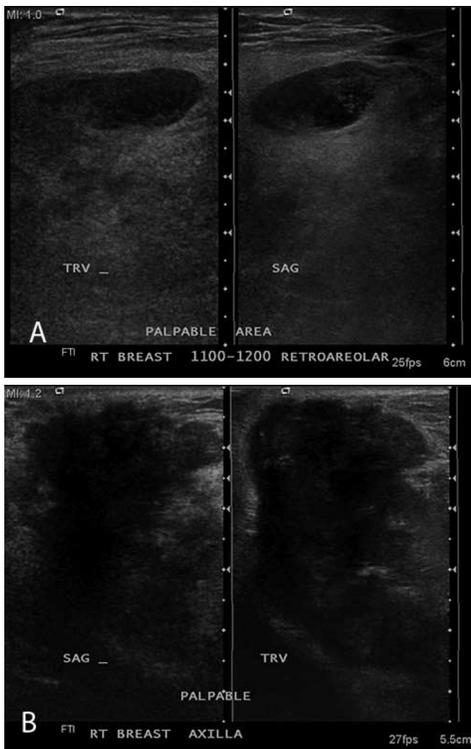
66-year-old male with dedifferentiated liposarcoma of the right breast. Targeted right breast ultrasound was performed in the areas of the palpable and the mammographic abnormalities. A. Transverse and sagittal images of the right breast, 11-12 o'clock region, show a 9.2-cm isoechoic mass with a 4-cm cystic component. B. Transverse and sagittal images of the right axilla show a 3.9-cm hypoechoic mass with irregular margins, suspicious for malignancy.
